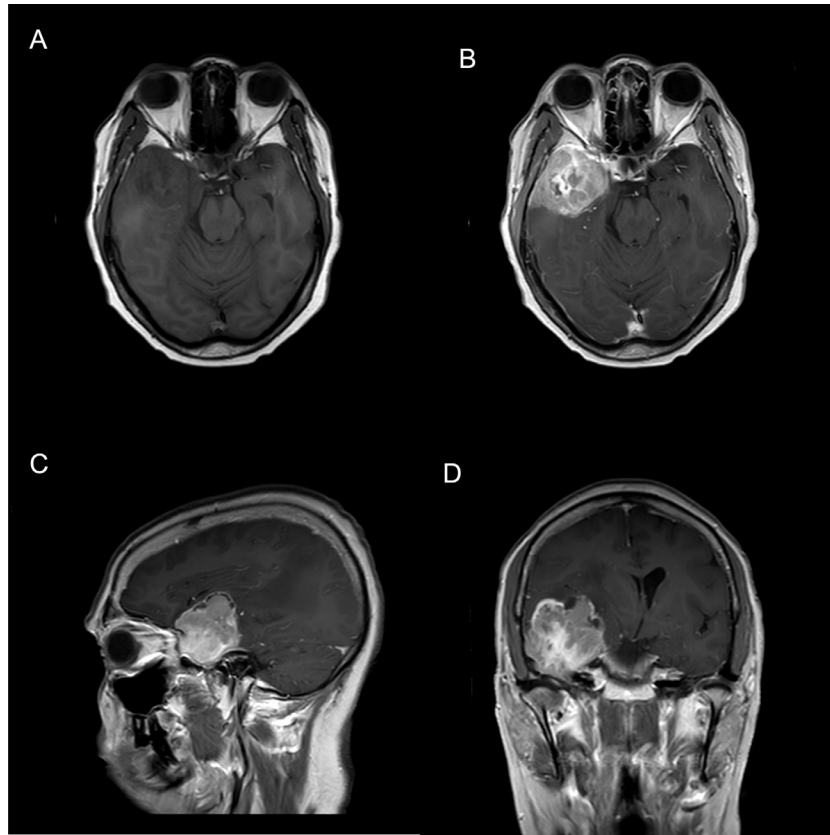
Preoperative MRI images with gadolinium. (A) MRI: Pre-Operative Axial T1 SE Non-Contrasted (B) MRI: Pre-Operative Axial T1 SE + Gadolinium Contrast (C) MRI: Pre-Operative Sagittal T1 SE + Gadolinium Contrast (D) MRI: Pre-Operative Coronal T1 SE + Gadolinium Contrast.
